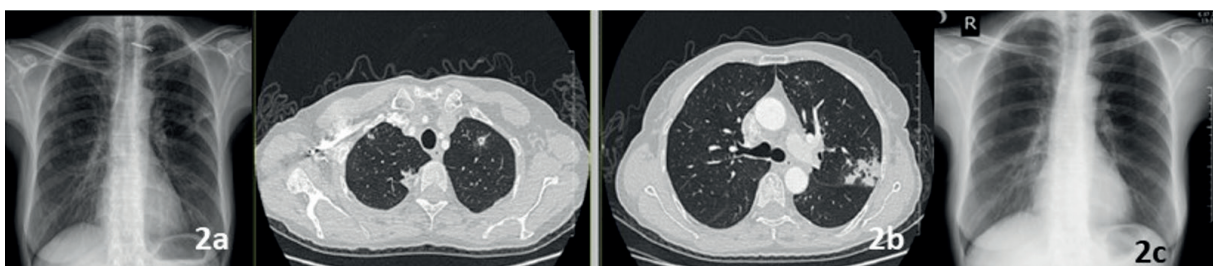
a: Density increase in bilateral mid-upper zone on chest X-ray, b: Nodule in the right upper lobe, cavitory nodule in the left upper lobe, and consolidation in thorax CT, c: Nodules are observed to regress in chest X-ray control.
